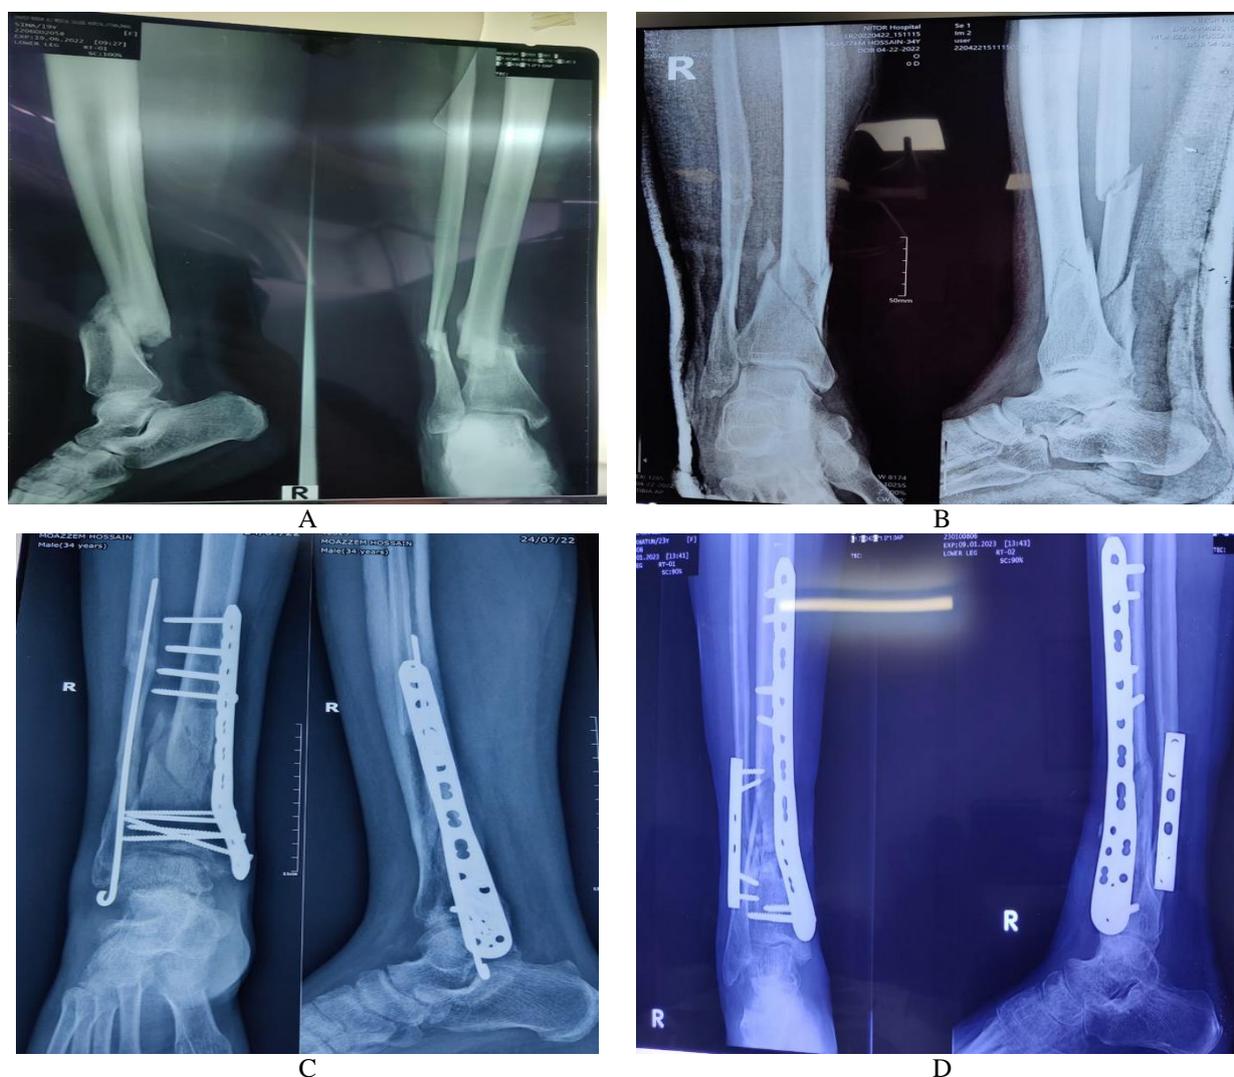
33 years old female, injured her right tibia after a traffic accident. She was operated with ORIF at 10 days post-injury. (a) Pre-operative anteroposterior radiograph of the injured tibia. (b) Preoperative lateral radiograph of the injured tibia. (c) Postoperative antero posterior radiograph of the tibia at 18 months follow-up. Bony union was achieved. (d) Postoperative lateral radiograph of the tibia at 18 months follow-up.
